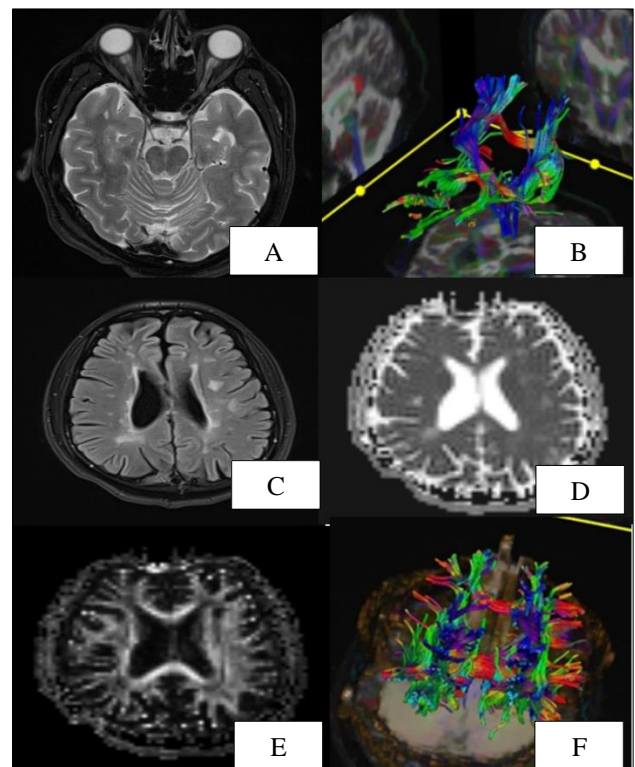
RRMS. Axial T2w fat sat image of brain (A) atrophic changes in bilateral optic nerve (orange arrow), 3D tractography image (B) loss of left sided optic nerve fibers (yellow arrow). Axial FLAIR image (C) hyperintense demyelinating plaques (yellow circle) in bilateral periventricular region. Lesions appear bright on ADC map, red circle (D) and dark on FA map, green circle (E) 3D Tractography image (F) fibre loss (blue solid arrow) in bilateral white matter tracts.
